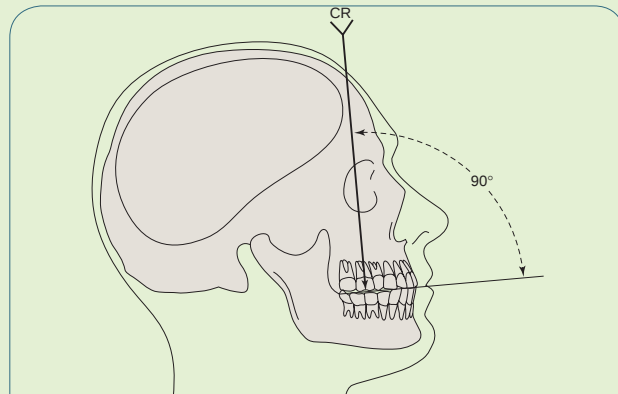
Cross-sectional occlusal radiograph of the maxillary arch.
